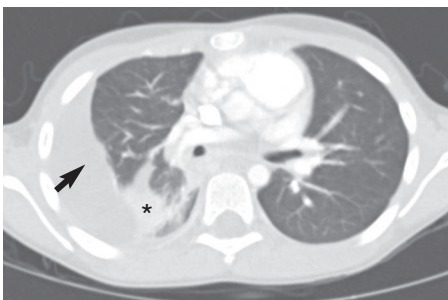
Chest computed tomography image showing a right-sided empyema along the right lateral wall (*arrow*) and a right lower lobe infiltrate between the empyema and the spinous process (*asterisk*).
